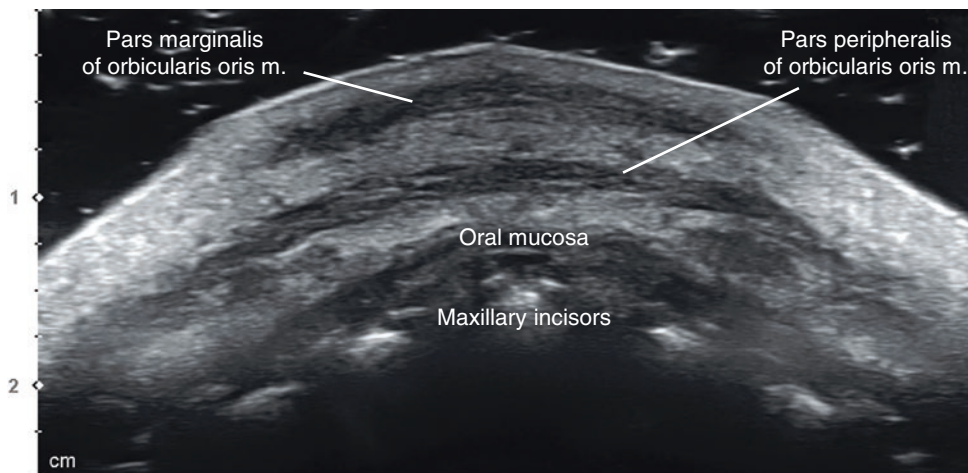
Ultrasonography of the intersection point of vermillion border of upper lip and midline (Ls1). B mode (transverse view, 15 MHz by linear transducer). (Published with kind permission of © Hee-Jin Kim 2020. All Rights Reserved)
